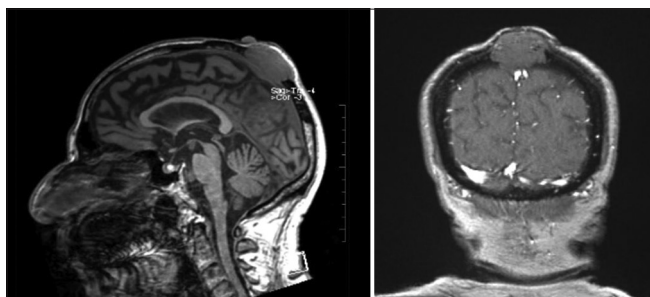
Magnetic resonance imaging brain with venography at 1st recurrence
